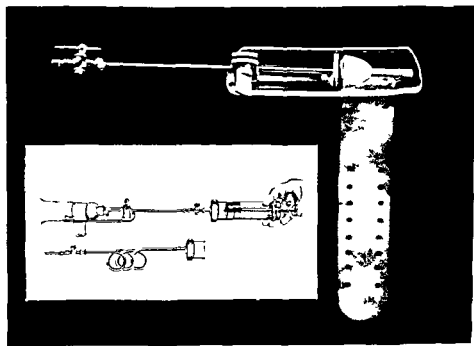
The instrument used for cysto urethrography. The inset shows the instrument attached for urethral filling during radiographic exposures. Normally a long rubber connection is used to enable adequate protective measures against X radiation to be taken.
